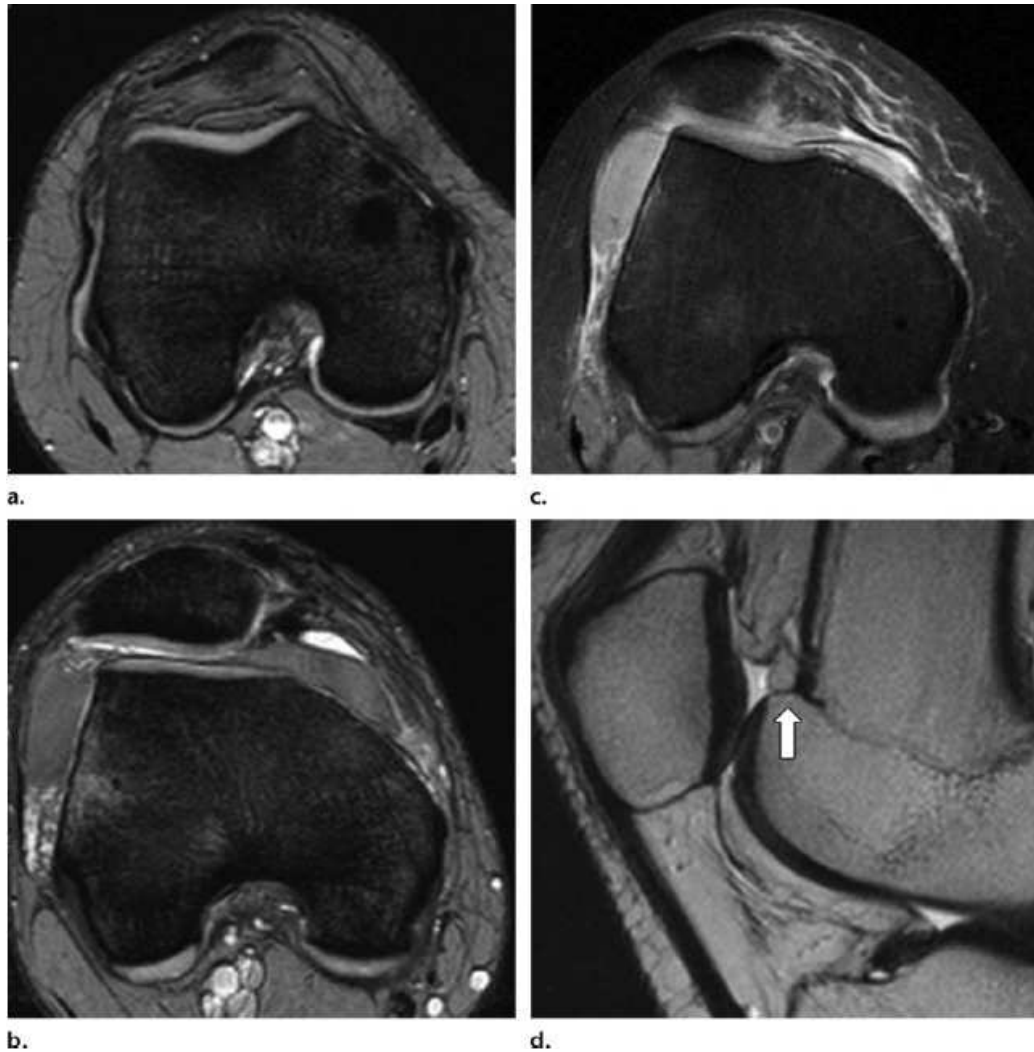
Typical radiographic finding of subjects with trochlea dysplasia (Diederichs, Issever et al.). Figures a, b, c, d follow the classification of Dejour (Dejour H 1994). Patients with Type A, and B, usually are not for surgical correction of the dysplasia.
